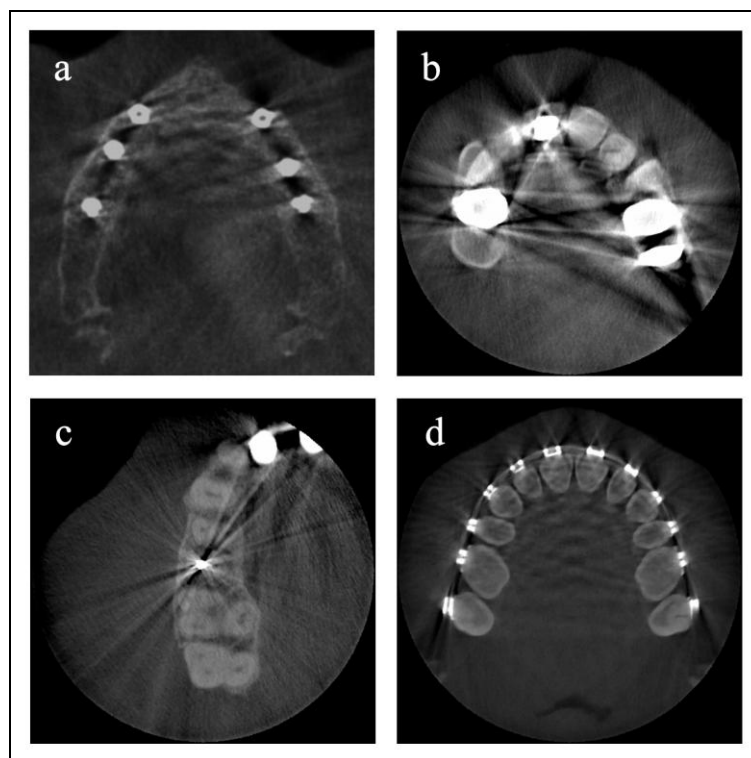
Examples of metal artefacts on cone beam computed tomography images in clinical practice due to (a) dental implants, (b) crowns, (c) endodontic filling and (d) orthodontic brackets.
